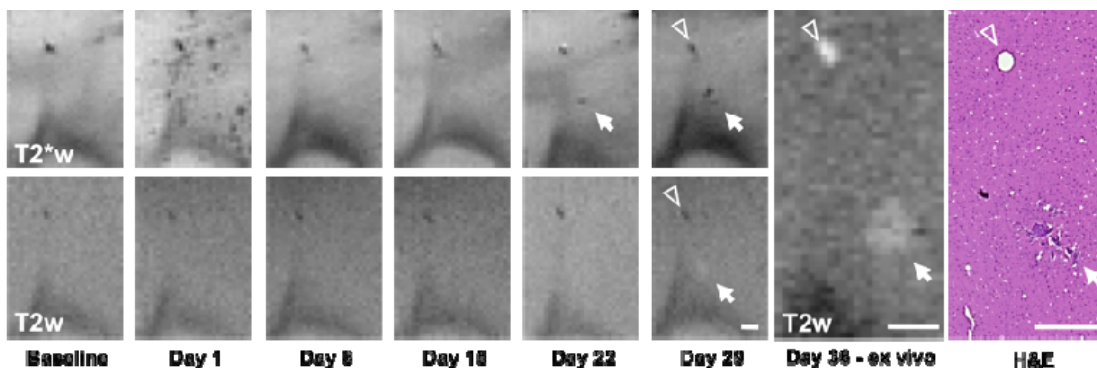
Serial T2*-weighted GE (top) and T2-weighted SE (bottom) images of the brain following injection of FePro labeled MD-MBA-231 cells. A developing tumor (arrows) is apparent on the T2*w image before detection on the T2w image. Baseline images are critical to differentiate tumors from large vessels (arrowheads). Scale bars indicate 0.5 mm.
